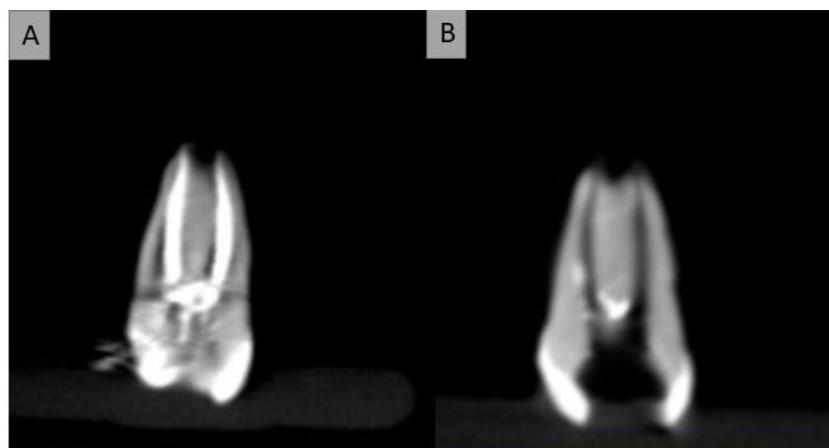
Representative images of CBCT after the obturation (A) and after the retreatment (B).
